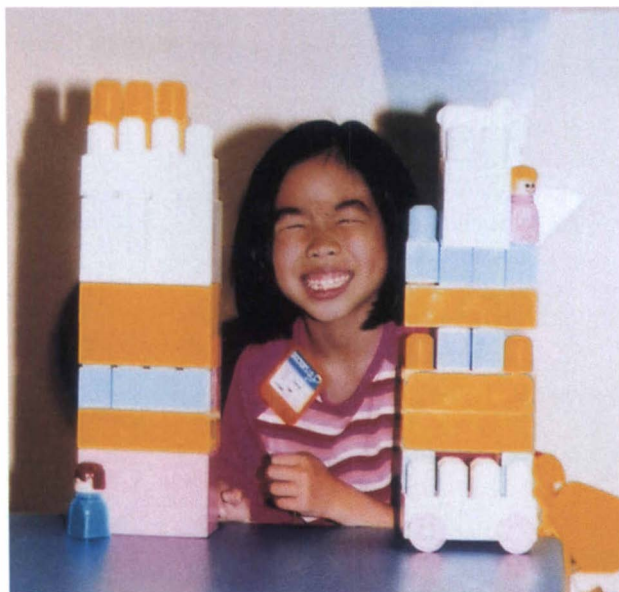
This little girl's face indicates a challenge for skull radiography.
